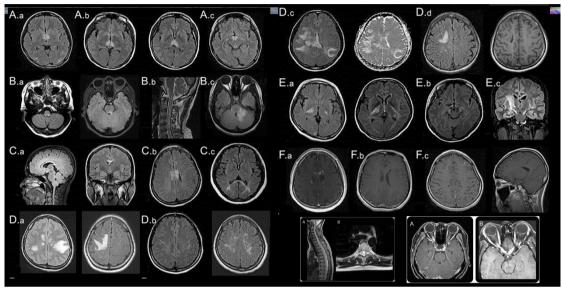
MRI in NMOSD Diencephalic lesions surrounding (A.a) the third ventricle and cerebral aqueduct (A.b) and including the thalamus, hypothalamus, and (A.c) anterior border of the midbrain (B.a) Dorsal brainstem lesion adjacent to the fourth ventricle (B.b) bulbar lesion linear contiguous with a cervical cord lesion (B.c) extensive edematous dorsal brainstem lesion involving the cerebellar peduncle. (C.a) Callosal lesion immediately adjacent to the lateral ventricle, following the ependymal border (C.b) Callosal lesion with marbled pattern (C.c) Callosal lesion with arch bridge pattern (D.a) Tumefactive hemispherical WML (D.b) Lance-shaped lesions or radial following WM tracts (D.c) Extensive and confluent hemispherical lesions with increased diffusivity in DWI maps suggesting the presence of vasogenic edema (D.d) Hemispherical lesions involving the posterior arm of the internal capsule and (E.b) the cerebral peduncle (E.c) longitudinal lesion of the pyramidal tract (F.a) Cloud-like enhancement, (F.b) linear enhancement of the ependymal surface of the lateral ventricles (F.c) meningeal enhancement Adapted from Ho Jin Kim, Neurology 2015
